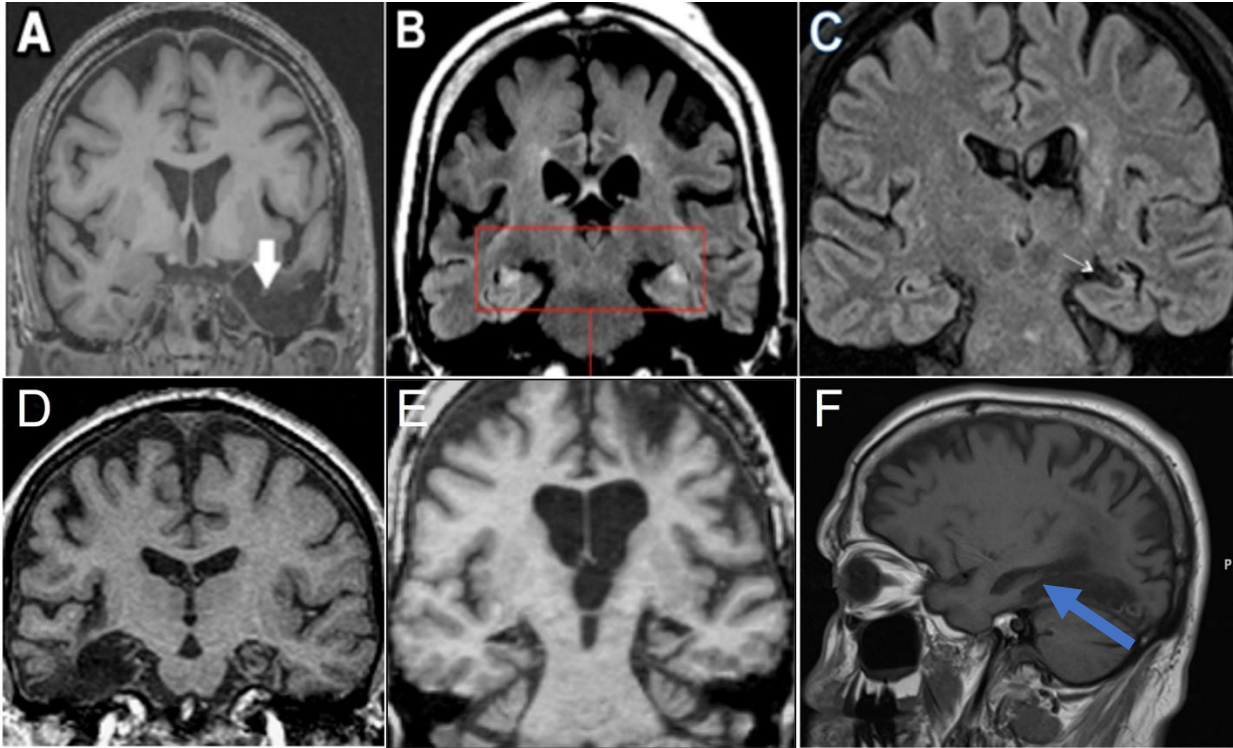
MRI images of MTL cases. Coronal T1-weighted image of medial temporal lobe damage for L.D. (A), B.L. (B), S.N. (C), D.A. (D), and K.C. (E). Sagittal T1-weighted image showing hippocampal volume loss for M.H. (F). Images are presented according to radiological convention (i.e., right hemisphere is presented on left side of image). Patients D.G., J.D., and J.M. could not be scanned because of contraindication. Scan for R.V. was unavailable. Details of lesion location and size are provided in the manuscript, and etiology, demographic information, and neuropsychological profiles are presented in Table 2.1.
